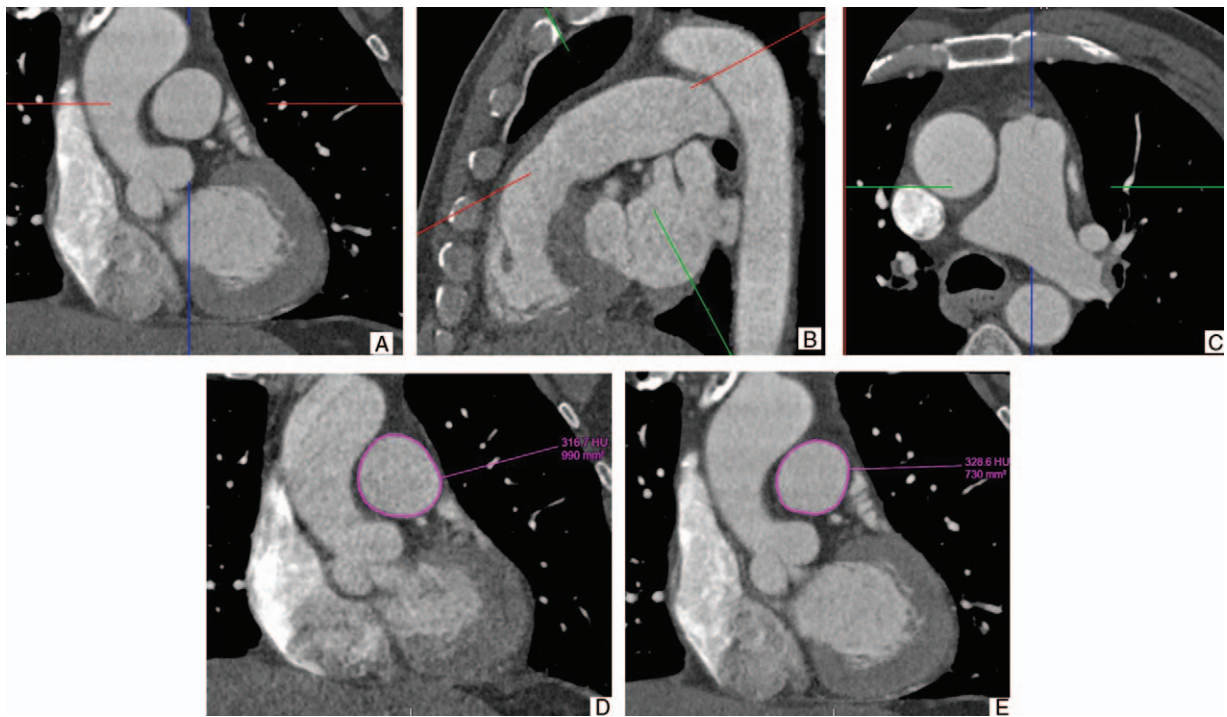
Computed tomography reconstruction plane for main pulmonary artery (MPA) cross-sectional area. (A) Coronal reconstruction of MPA cross-section after correction for its double obliquity. The plane of reconstruction used for cross-sectional area measurement was adjusted to be perpendicular to the MPA on both (B) sagittal and (C) axial views. The manual measurement method of MPA at (D) systolic and (E) diastolic.
